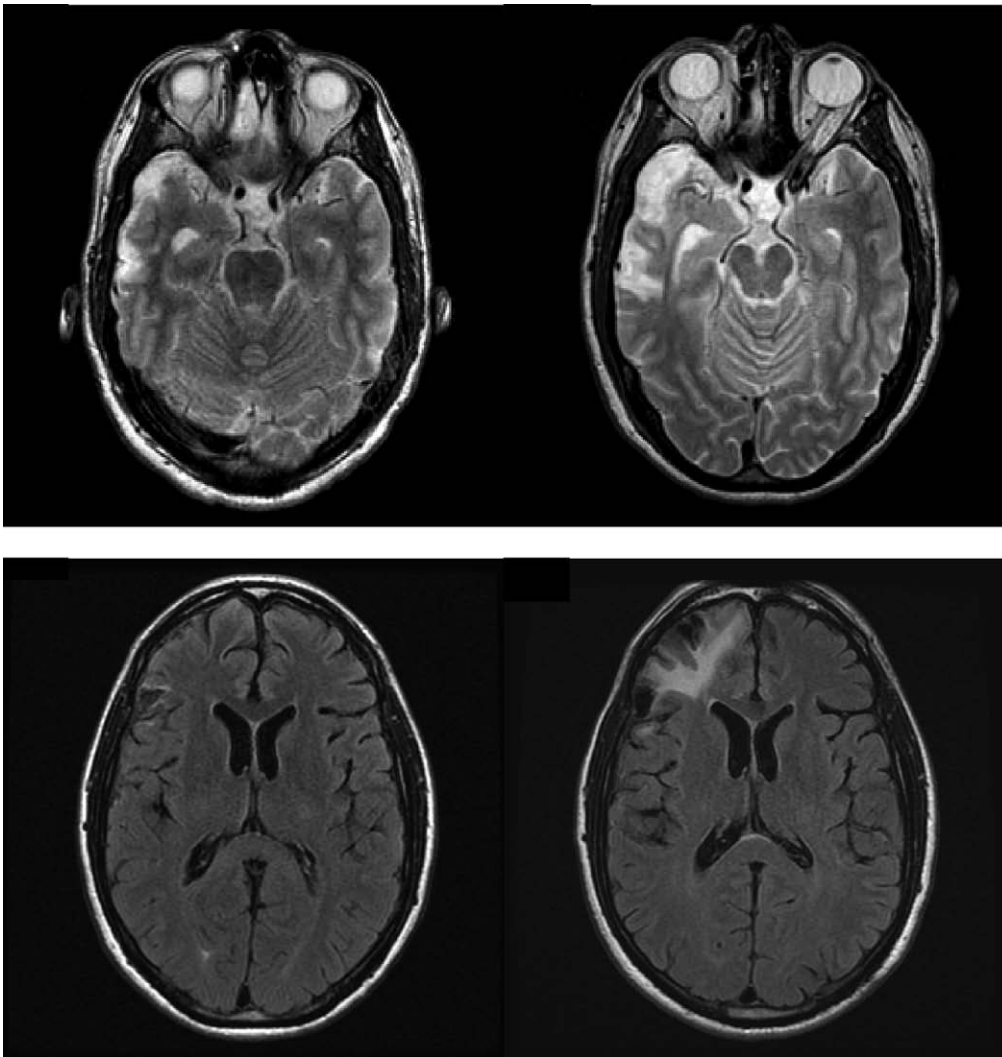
Example of lesion progression from 4.5 months postinjury (left) to 2.5 years postinjury (right) in 2 different patients. Top, T2 axial images demonstrate significant progression of localized atrophy of the right temporal pole extending posteriorly to the mid right temporal lobe that lies superior to the petrous temporal bone. There is also localized dilatation of the right temporal horn. Bottom, FLAIR axial images demonstrate marked progression of localized atrophy in the right frontal lobe with associated adjacent gliosis, where there were only subtle changes on the initial MRI.
